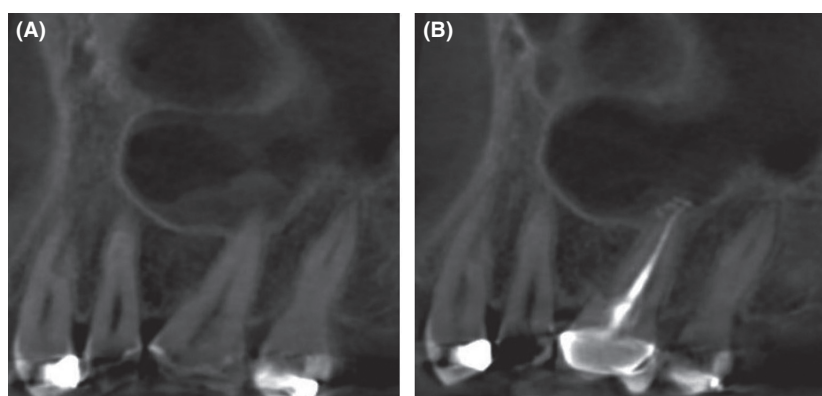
CBCT (A) before and (B) after 12-month GentleWave Procedure P Root.
